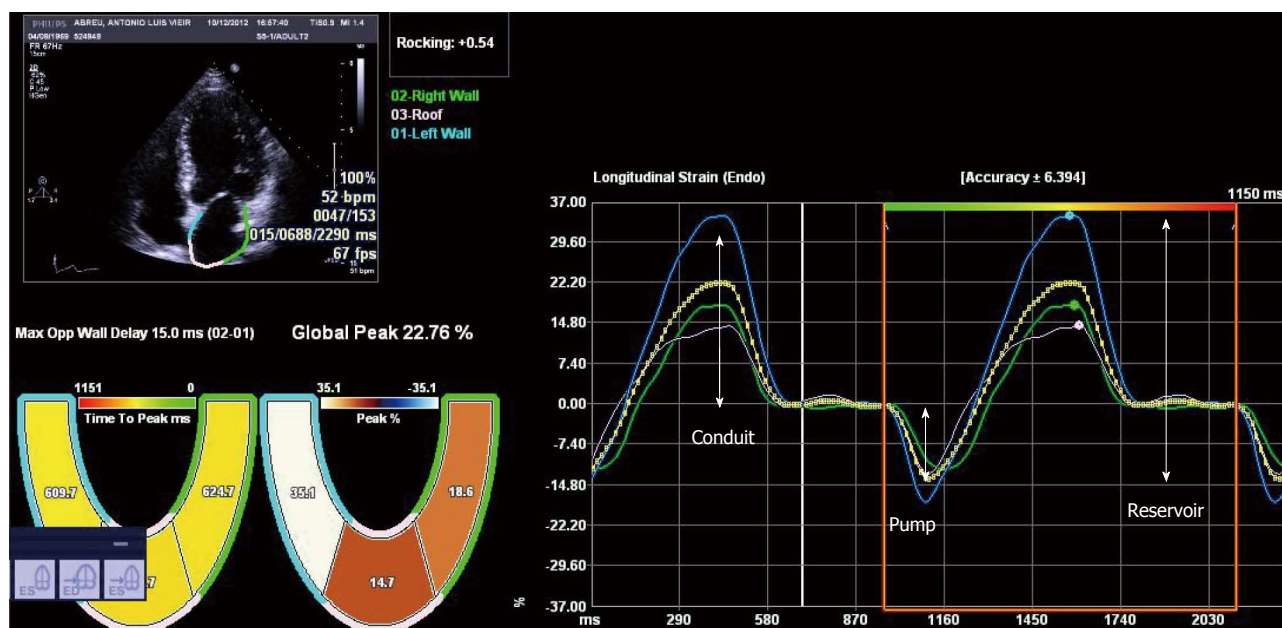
Left atrial deformation analysis using speckle tracking echocardiography. Reservoir, conduit and pump function of the left atrium during the cardiac cycle can be quantified from the strain curves.
